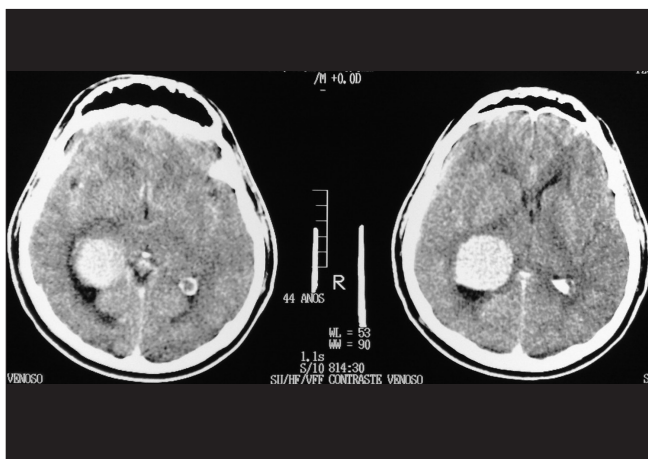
Preoperative imaging, brain computed tomography scan (with contrast)
